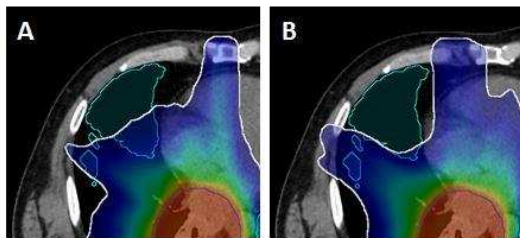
Transverse views of anatomically guided (A) and functionally guided (B) VMAT plans for a representative patient. Cyan contour indicates the ventilated volume within the lung as defined via  $^3\text{He}$  MRI. White contour shows the 20Gy isodose, which can be seen to preferentially avoid the ventilated volume in the functionally guided plan.
